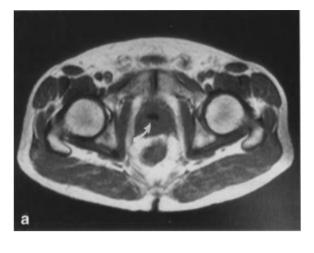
a-c. MR images of BPH. a Axial view; T1weighted spin-echo image obtained at 0.5 T. The prostate appears homogeneous; the central low intensity structure (arrow) represents the urethra with a post-TURP defect. b,c Axial and coronal T1-weighted images show the prostate (arrow) to be inhomogeneous with discrete hyperplastic nodules indenting the bladder base
